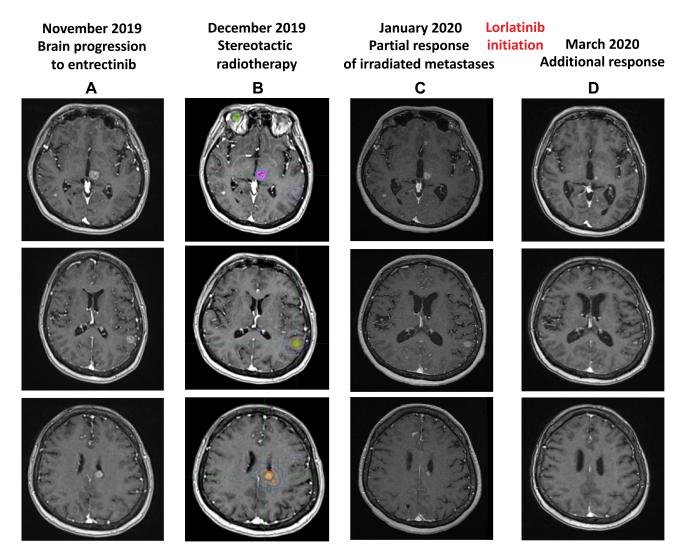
Figure I MRI evolution of brain metastases after fractionated stereotactic brain radiotherapy (A–C) and lorlatinib treatment (D). Three out of the five lesion treated with stereotactic radiotherapy are depicted (B), in the left thalamus (upper panel), left parietal lobe (middle panel) and left lateral ventricle (lower panel). In the upper panel, a contra-lateral sub-centimetric parietal lesion, visible in the first three MRI (A–C), is no more detectable after lorlatinib initiation (D). MRI sequences are 3D MP-RAGE (magnetization prepared – rapid gradient echo) after administration of chelate of gadolinium.
